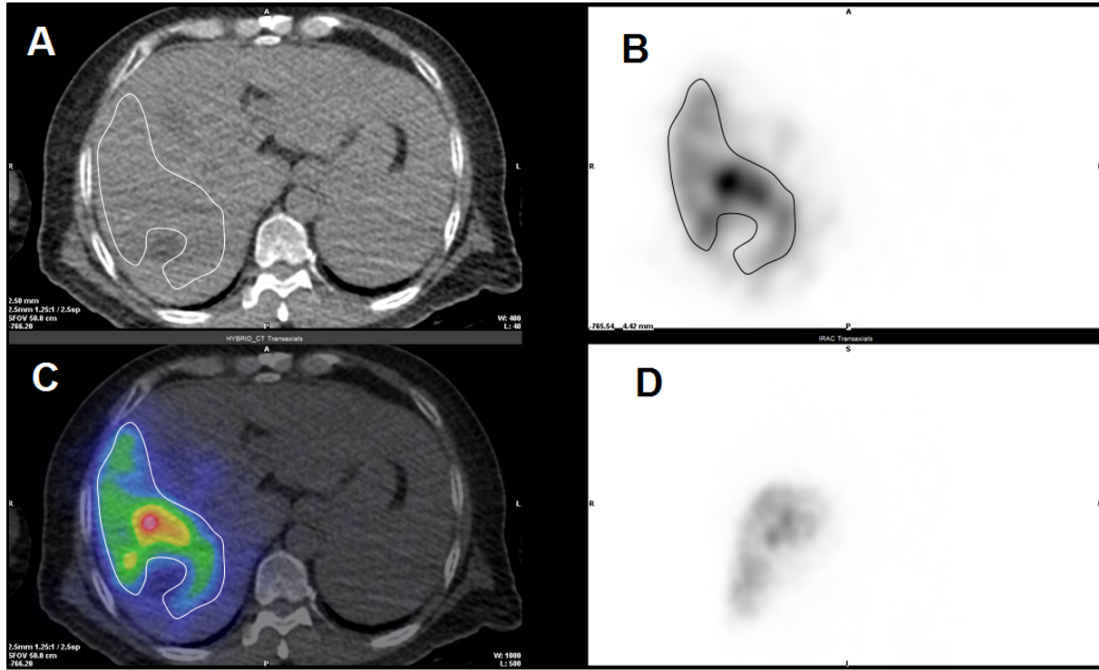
An example of SPECT/CT images of the liver with ^{99m}Tc -MAA injection. Image A is the non-contrast CT image of the liver. Image B presents the SPECT image at the same axial slice. Image C shows the overlaid SPECT image on the CT image. Image D depicts the corresponding sagittal view of the SPECT image.
